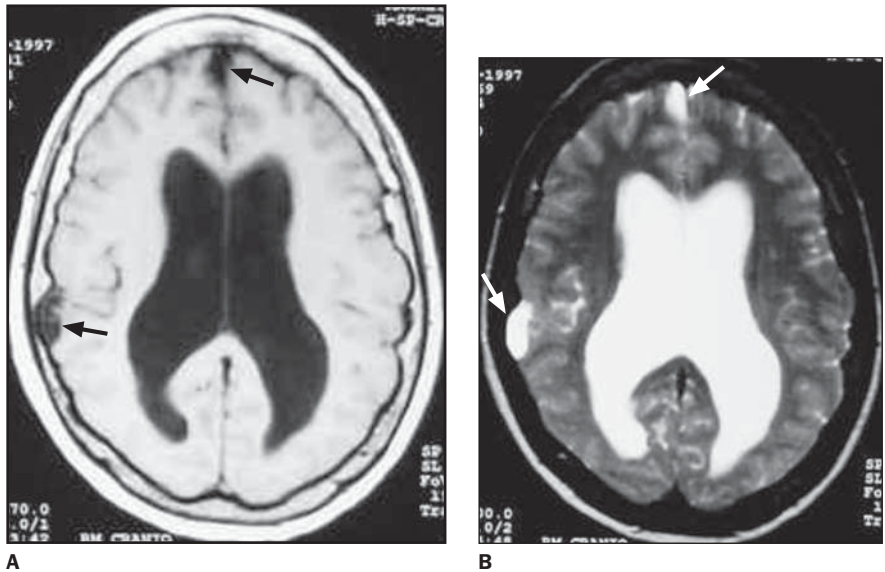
Axial brain MRI. A: T1-weighted showing hypointense cysts (arrows) in subarachnoid space in parietal and right frontal regions. B: T2-weighted sequence at the same level, showing hyperintense cysts (arrows).
